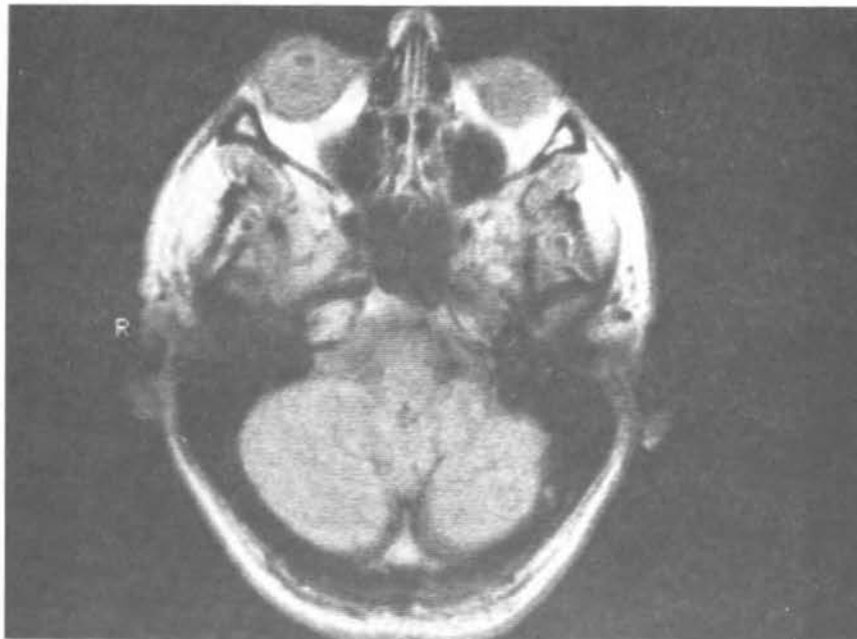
Clear and detailed MRI image of section through human head. Figure courtesy of L. Kaufman.
